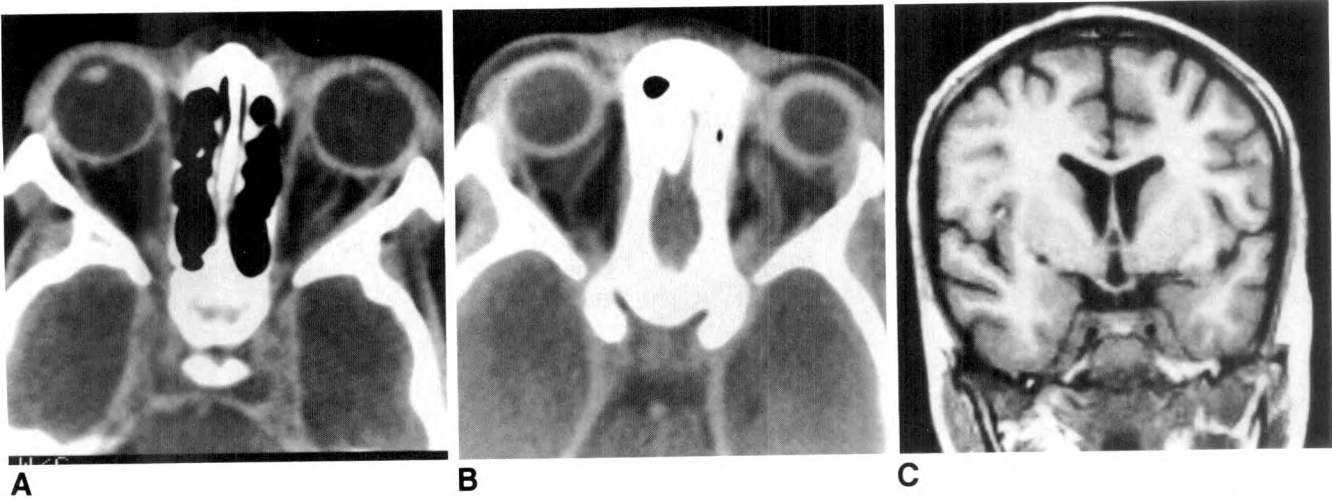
Case 2: 6-year-old girl with recent onset of periorbital swelling and proptosis. A, B, CT scans of orbits and parasellar region with IV contrast material. C, Coronal MR image (TR = 500 msec, TE = 17 msec).
